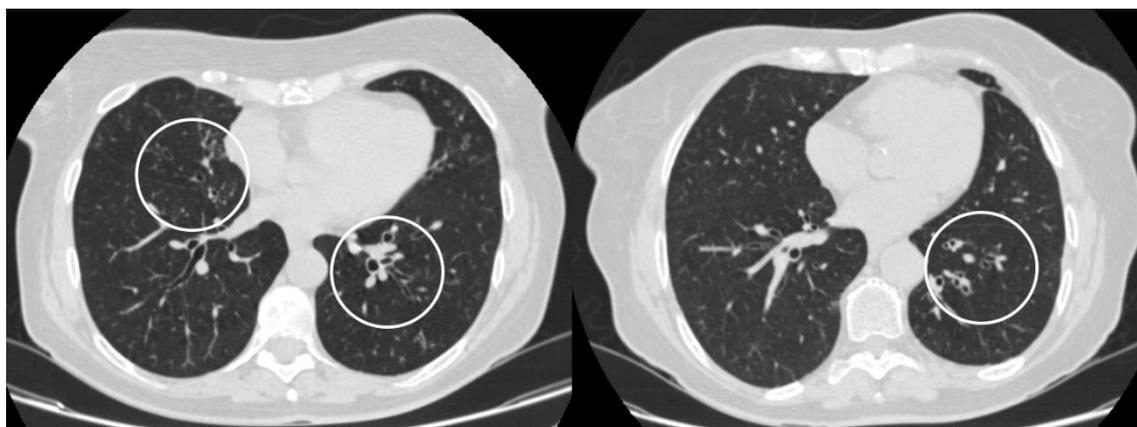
Thorax high resolution computed tomography from patients with rheumatoid arthritis showing bronchoarterial ratio >1 , in relation to bronchiectasis (circle)
